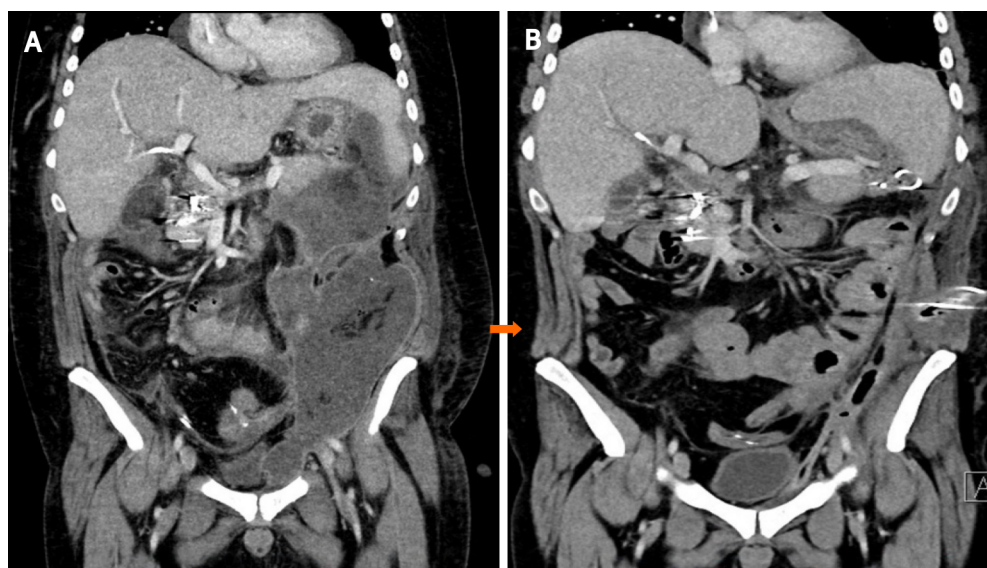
Case 1. Coronal computed tomography with walled-off necrosis. A: Before drainage; B: After 86 d and 14 procedures.
